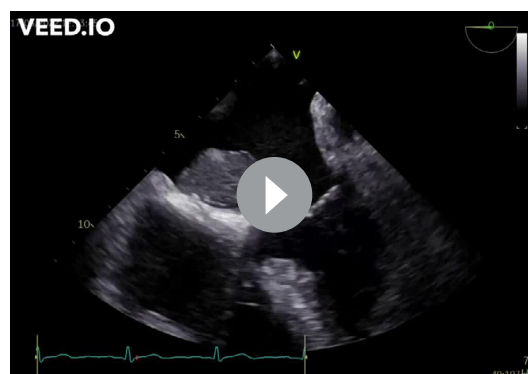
Transthoracic echocardiogram showing a large elongated mobile mass in the left atrium.
